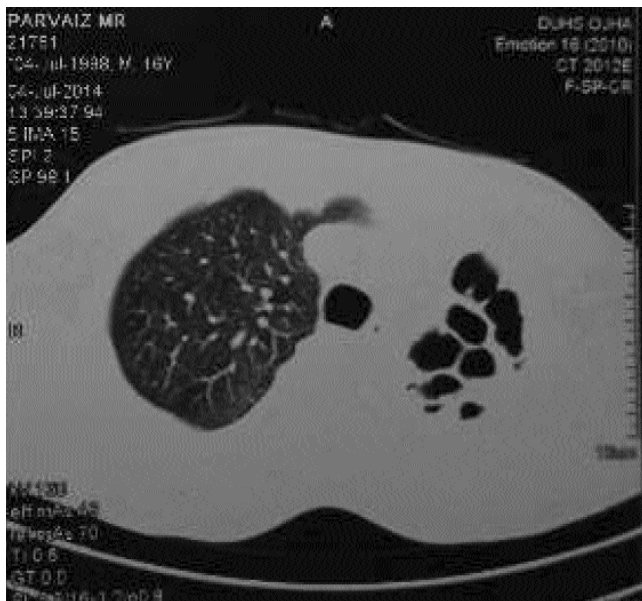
Computed Tomography scan of lung window showing extensive bronchiectatic changes in left lung.
